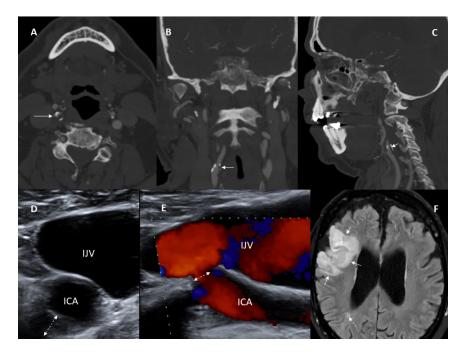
A 72-year-old man with hypertension and previous smoking was admitted with acute left-sided central facial palsy and palsy of the arm, and visual neglect to the left. CT of the brain showed an extensive established frontal infarction on the right side within the supply of the middle cerebral artery, and supplementary CT angiography visualized a carotid stenosis of 70% on the right side (arrows in Fig 5A-horizontal view, B- coronal view, C-sagittal view). The backwall plaque at the origin of ICA was seen on ultrasound (dashed arrow – Fig 5D) and the grade of stenosis (dashed arrow) was reproduced on color doppler ultrasound (Fig 5E). A concomitant acute myocardial infarction complicated management and prolonged time to thrombendarterectomy of the symptomatic carotid stenosis. A magnetic resonance tomography of the brain six days after the cerebral event showed a 6 x 5 cm large, current ischemic lesion in the right posterior central gyrus, posterior lobe (dashed arrow – Fig 5F). ICA, internal carotid artery; IJV, internal jugular vein. © Department of Radiology, Skane University Hospital.
